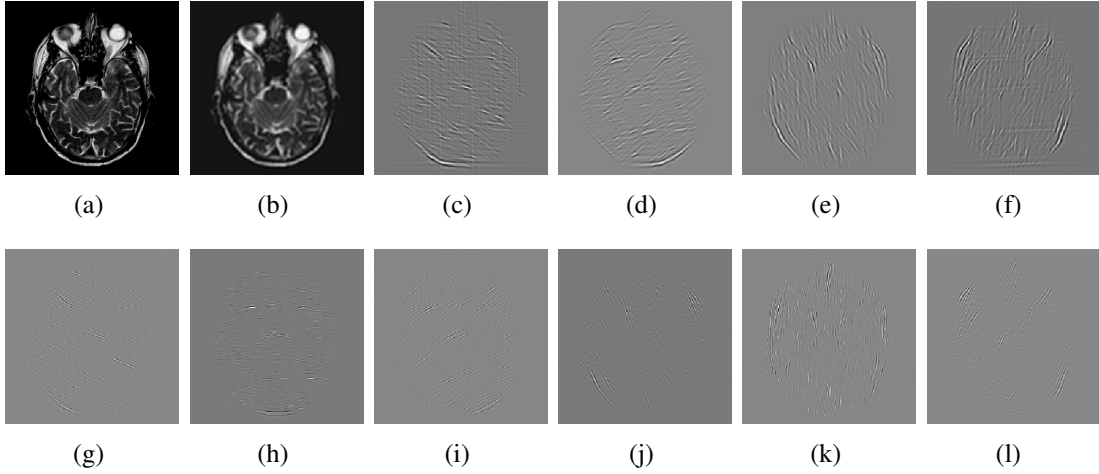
An example of two pyramidal scales nonsampled shearlet transform (NSST) decomposition. (a) MR image of an Alzheimer’s disease patient. (b) The low-frequency subband. (c)-(f) The high-frequency subbands at scale 1. (g)-(l) The high-frequency subbands at scale 2.
